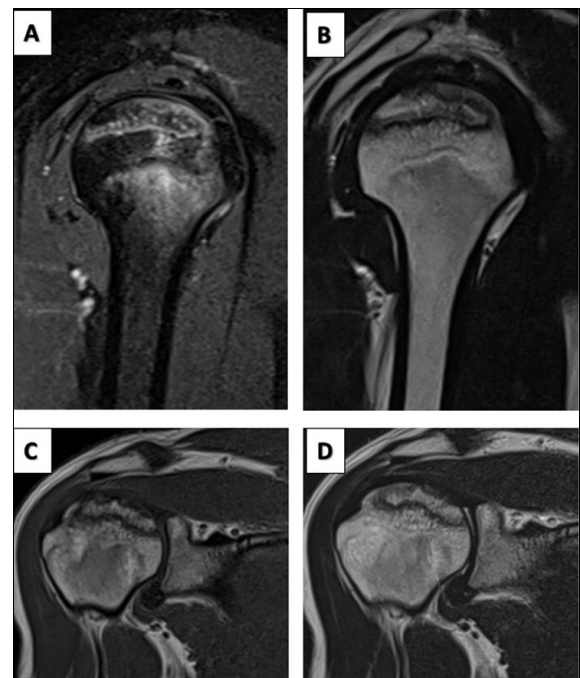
MRI of shoulder which revealed involvement of the humeral heads bilaterally
